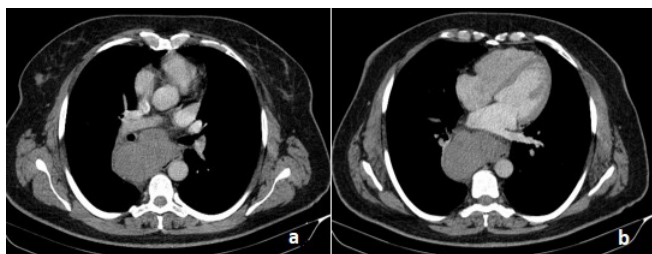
Thorax CT showing the mass lesion, (a) pushing the distal part of the right main bronchus, (b) causing an external compression to the esophagus lumen.
